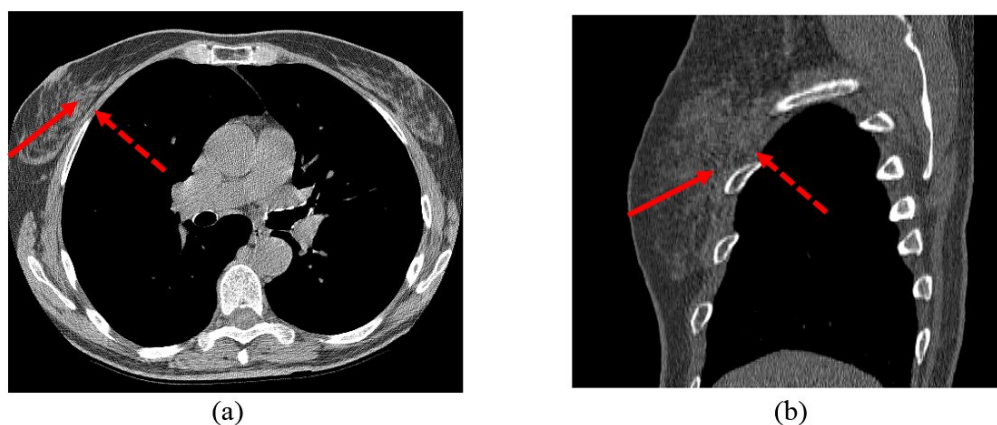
CT (a) axial slice and (b) sagittal slice. Solid arrows mark glandular tissues in the breast and dashed arrows mark the muscles in the pectoral regions.
